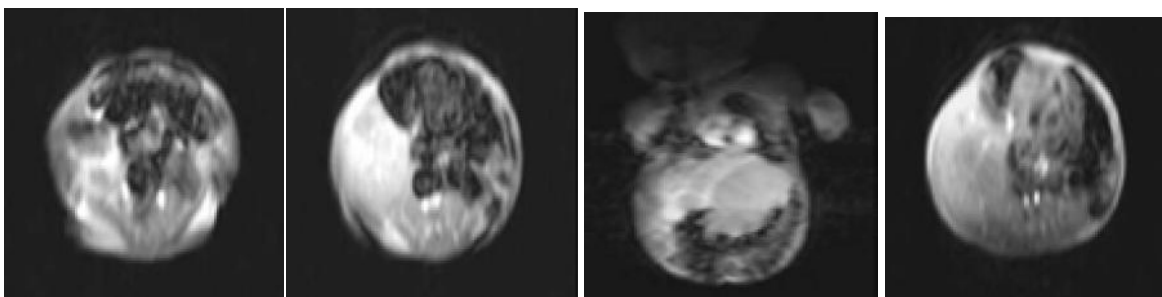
MRI in the age of 1-month-old showing a large, dominantly cystic hepatic mesenchymal hamartoma
